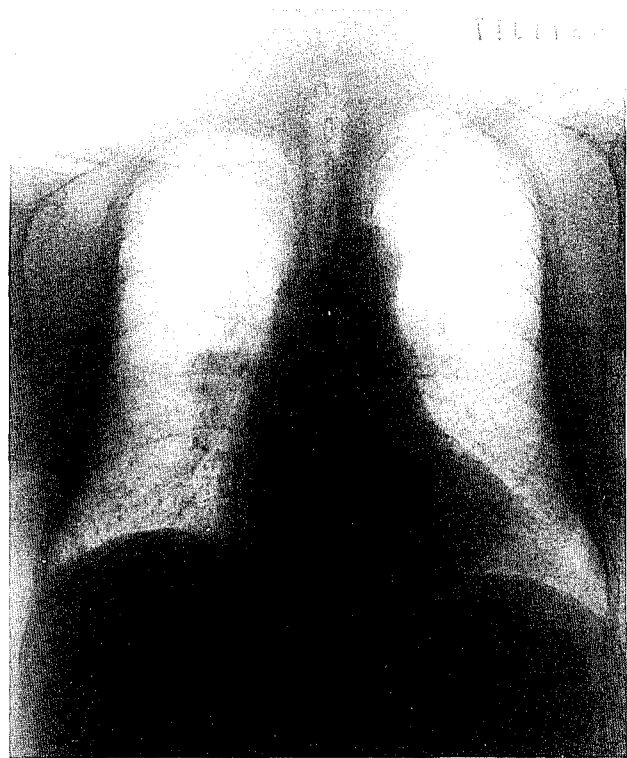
Chest radiograph obtained in 1997 does not show a left breast shadow
